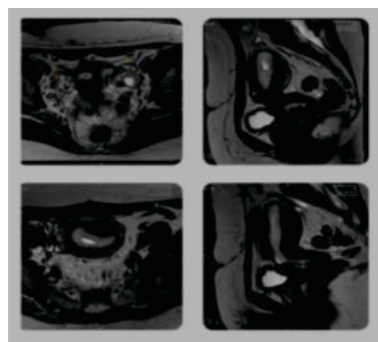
MRI Images Of Patient.
